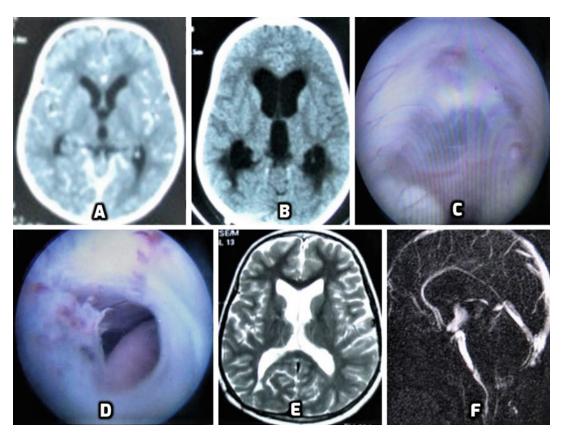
ETV in an opaque third ventricle floor (a) Axial post-contrast CT image showing no hydrocephalus. (b) Axial plain CT image showing hydrocephalus. (c) Endoscopic view of the thin translucent third ventricular floor. (d) Endoscopic view following third ventriculostomy. The
